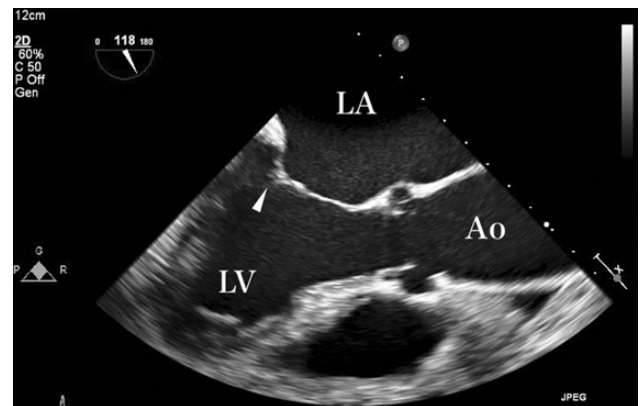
Preoperative transoesophageal echocardiography: long-axis view in mid-systole. The white arrowhead shows coaptation between the anterior and posterior leaflets. Mitral annular dilatation and LA dilatation are shown. LA: left atrium; LV: left ventricle; Ao: ascending aorta.
